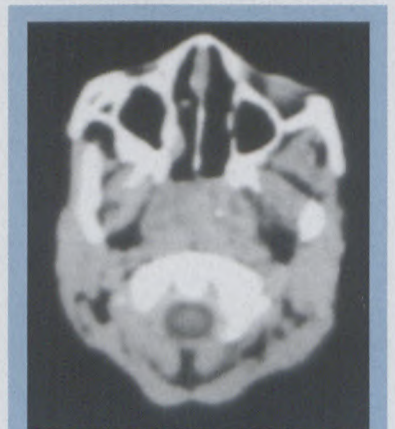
CT of nasopharynx. Approximately five-year-old child. Previous adenoidectomy failed to cure snoring. Conventional radiograph similar to Figure 2.
